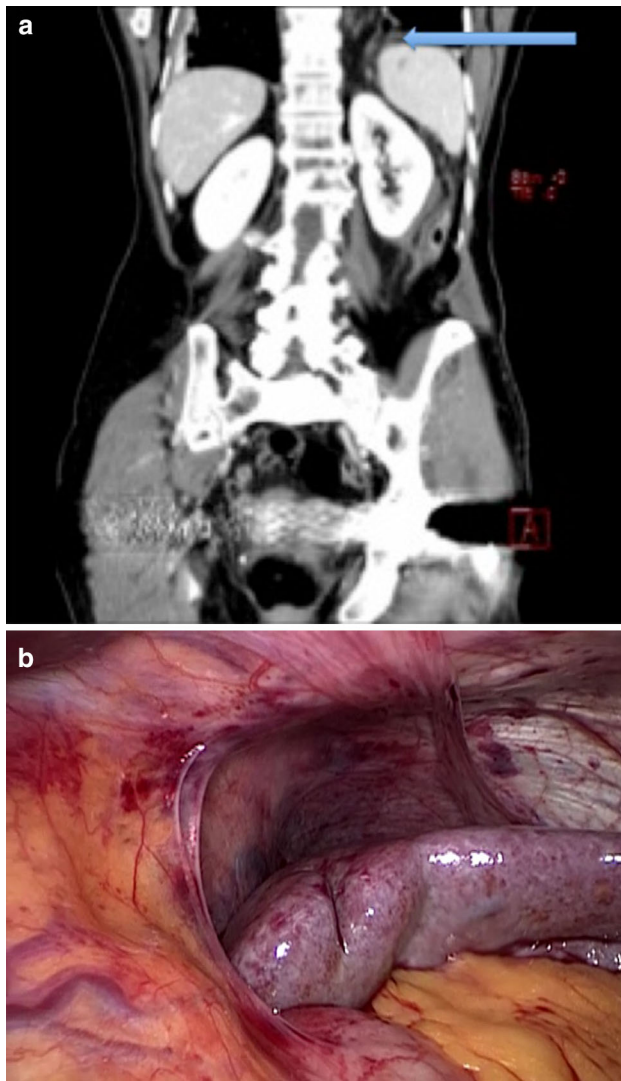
a CT suspicious for left-sided diaphragmatic injury and a small lesion of the splenic pole. b Laparoscopic view of the diaphragm excluding a diaphragmatic rupture but confirming the splenic injury that was treated with fibrin glue and collagen fleece
